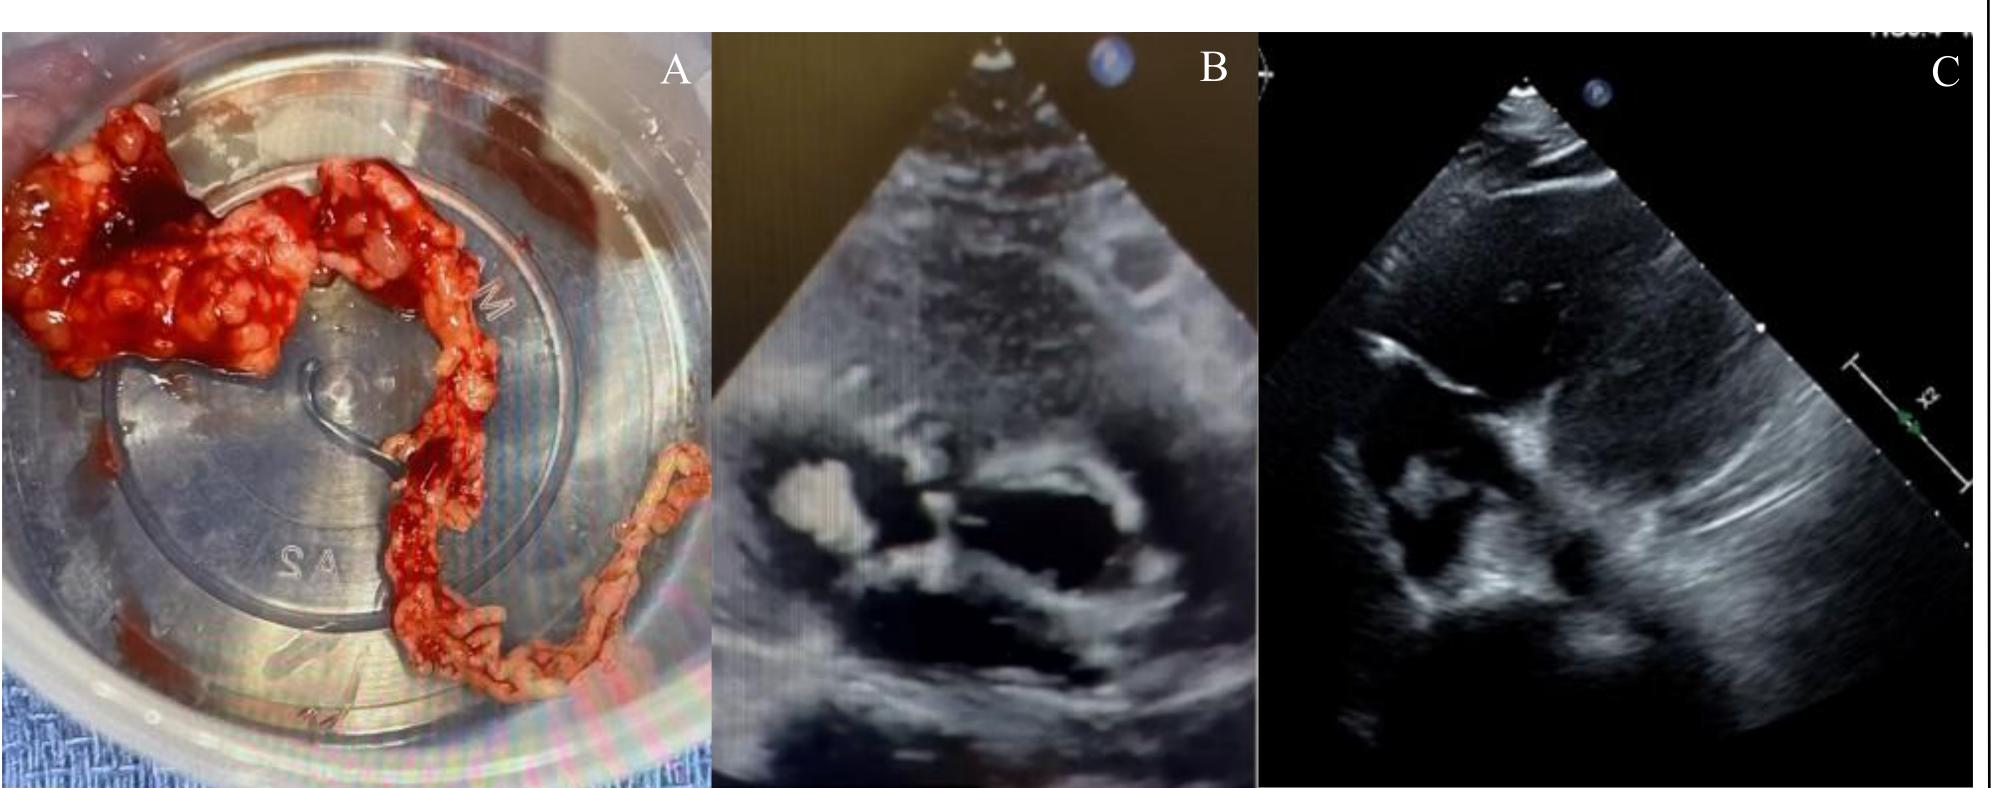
Tumor recovered from aspiration device; Figure B:Point-of-care ultrasound (POCUS) displaying clot in right atrium on image left; Figure C: Formal transhroacic echocardiogram displaying apical four-chamber view of clot in the right atrium on image
